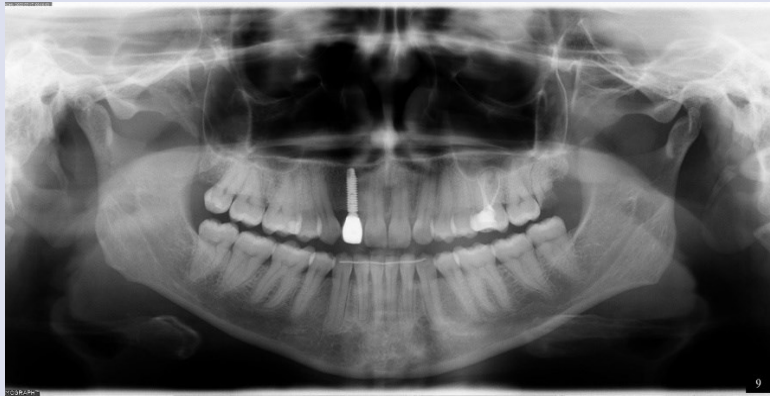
Radiograph of the final restoration at 3 months
